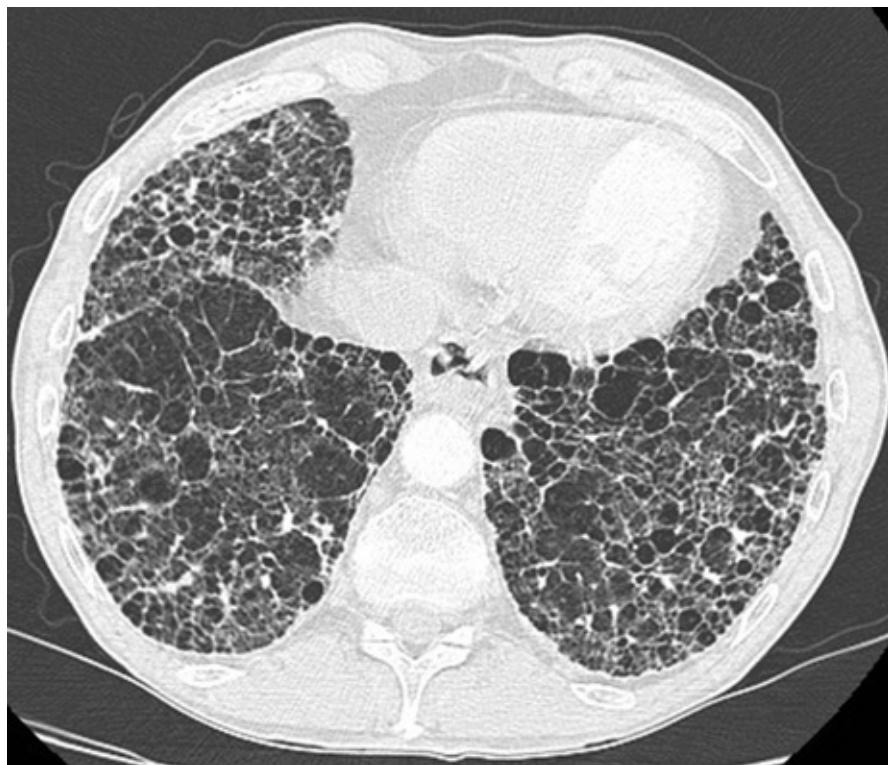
HRCT lung window settings. HRCT of a 76-year-old man with an 8-month history of increasing breathlessness and dry cough. Spirometry showed a restrictive deficit with reduced transfer factor. The HRCT shows typical honeycombing.
